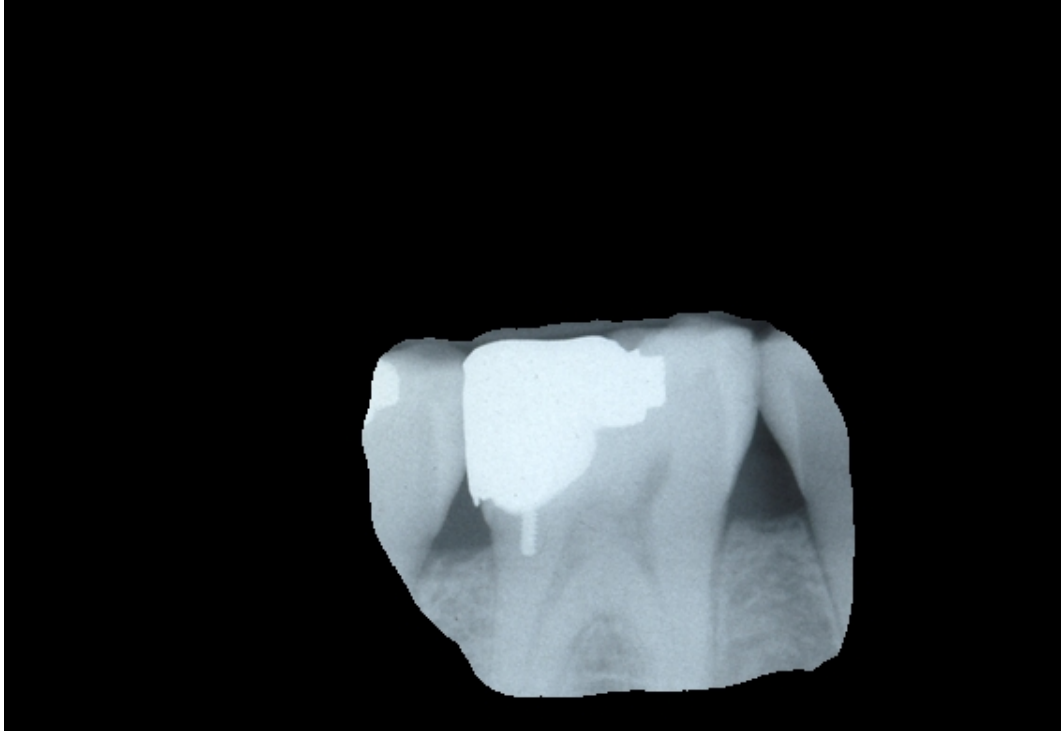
Contents of the ROI for a single radiograph
